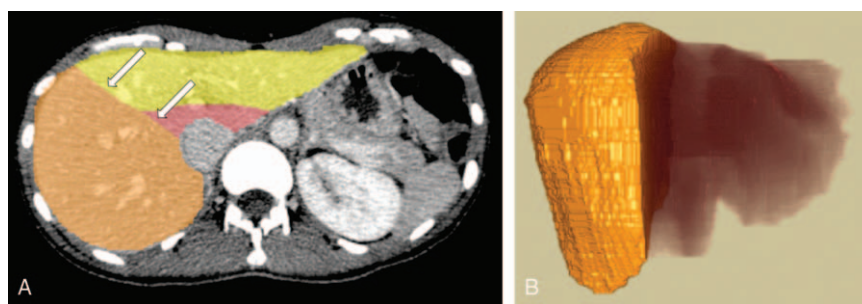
Computed tomography (CT) volumetry for the liver graft. The graft is traced with the cutting line along the middle hepatic vein (arrows) on the axial CT image in the venous phase (A). Volume-rendering 3D image (B) shows the total volume of the graft (637 mL). The accurate graft weight was 590g.
